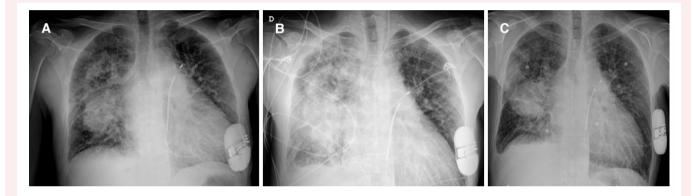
Chest radiography at admission (A), after epoprostenol initiation (B), and after epoprostenol withdrawal and furosemide initiation (C).
